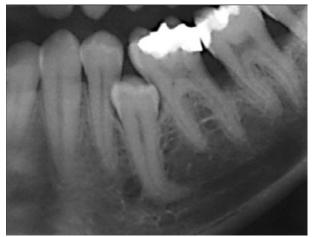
Cropped panoramic radiograph depicting the obstructed eruption path of mandibular left premolar tooth #20.
